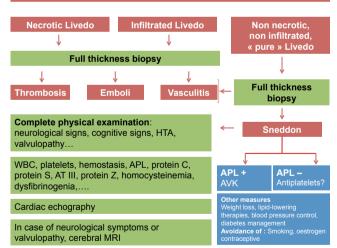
Algorithm for the management of livedo in adults. APL: circulating antiphospholipid; AT III: Anti-thrombin III; AVK: anti-vitamin K treatment; HTA: health technology assessments; MRI: magnetic resonance imaging; WBC: white blood cells.
